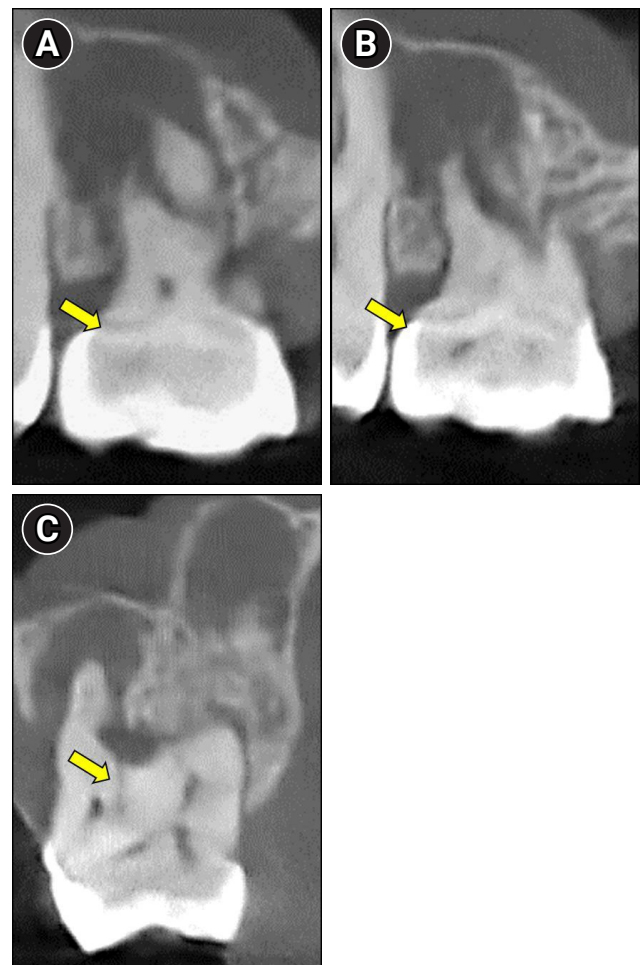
Cone-beam computed tomography images revealing characteristic anatomical features of molar-incisor malformation. (A, B) A dense mineralized structure consistent with a cervical mineralized diaphragm (yellow arrows). (C) An open channel (yellow arrow) connecting the furcation region to the pulp chamber.
